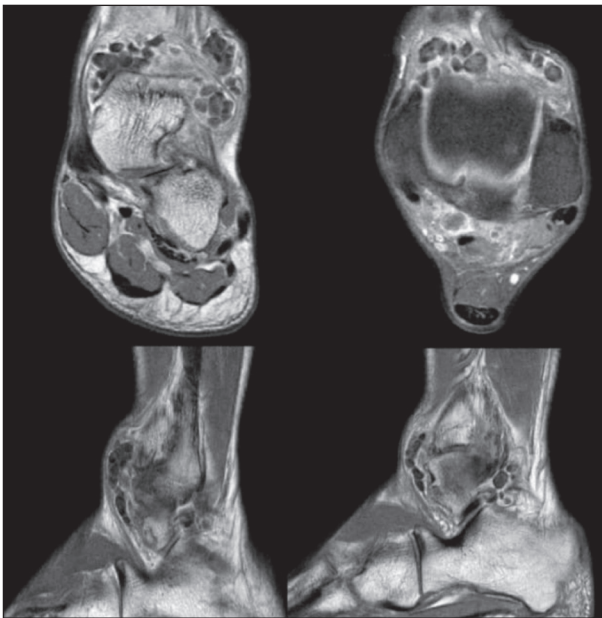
MRI images show multiple loose bodies that are filling and distending the synovial recesses.
